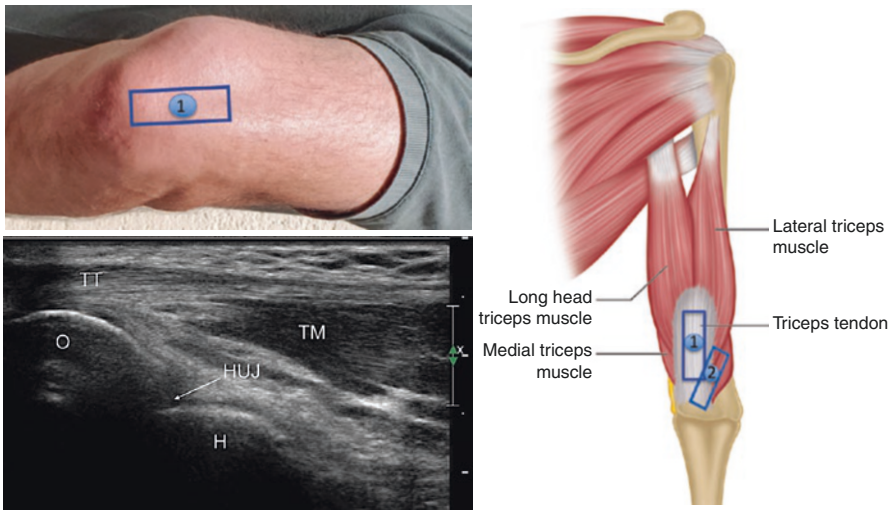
Sonoanatomy of the posterior elbow with the ultrasound probe in the scan position 1
